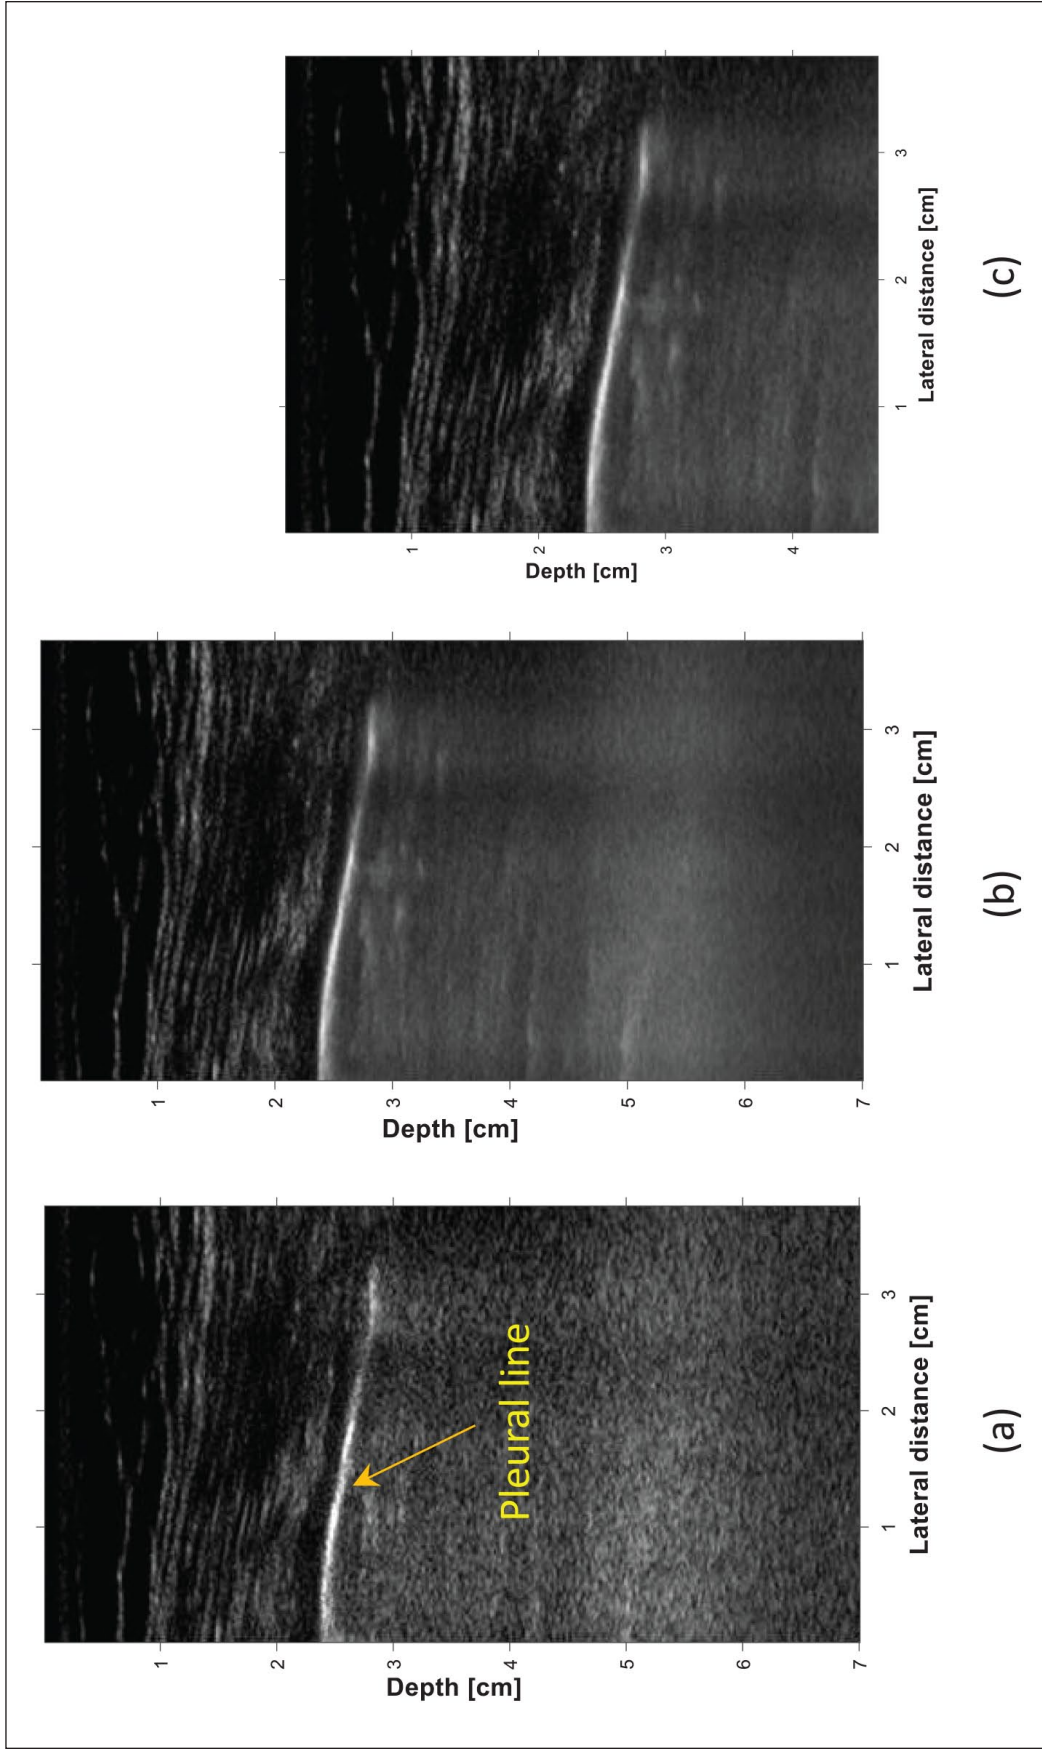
The ultrasound images showing the pleural line. (a) A single frame. (b) An averaged image. (c) The image of reduced size.
